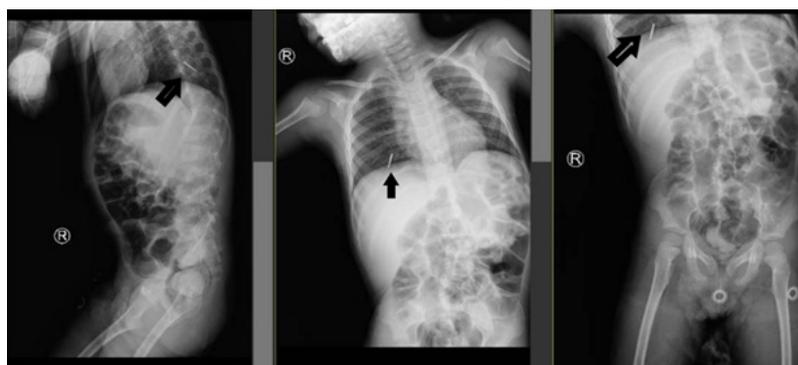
X-ray showed foreign body in right lung lower zone.
